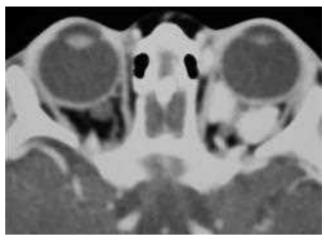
Imaging of capillary haemangioma. Axial enhanced CT showing a homogeneous intraconal orbital soft tissue mass
